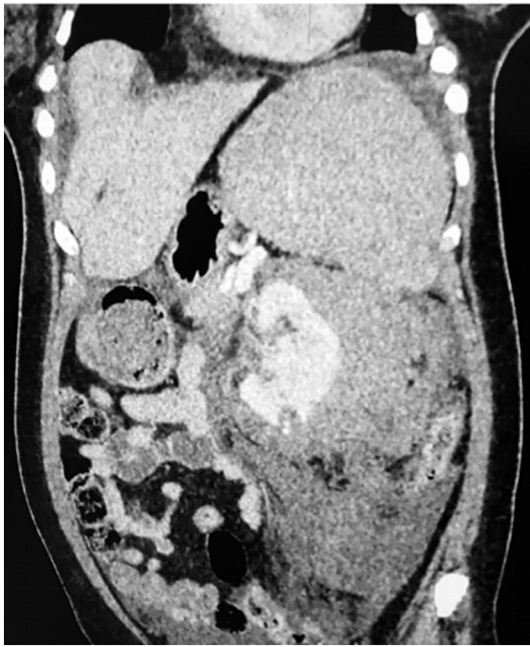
Contrast computed tomography (CT) (coronal section) shows large left perinephric hematoma with compressed, medially displaced kidney with small renal infarction and contrast leak at biopsy site (marked with a pointer).
